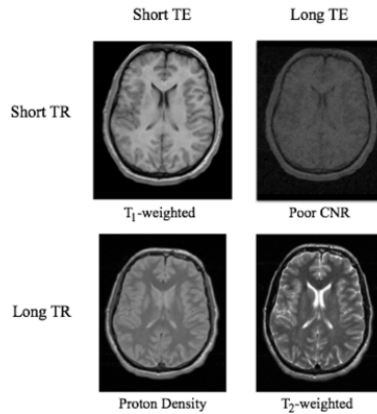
The choice of TE and TR determines the type of contrast. Notice that for T1-weighted images, cerebrospinal fluid is dark, and white matter is brighter than grey matter. For T2-weighted images, the cerebrospinal fluid appears bright, and the white matter appears darker than grey matter. (from [24])
